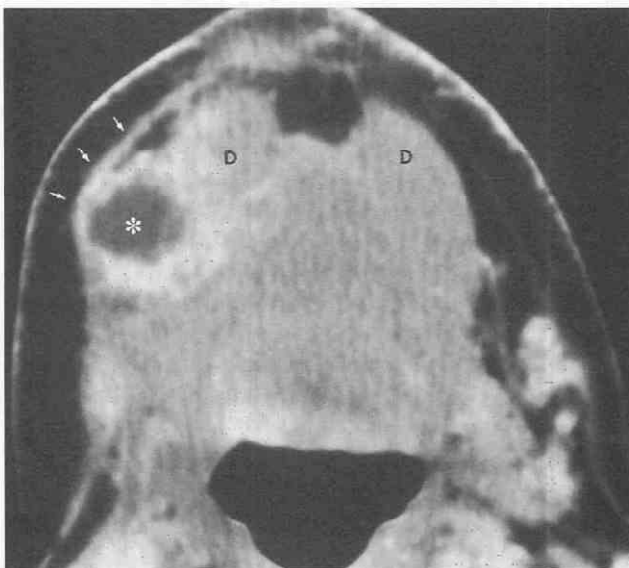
Metastatic lymph node mimicking abscess. Axial contrast-enhanced CT scan demonstrates a low-density right submandibular triangle mass (*asterisk*) surrounded by an irregular rim of contrast enhancement. The overlying platysma muscle is thickened. The patient, who was afebrile, had a history of treatment for squamous cell carcinoma of the right oropharynx 2 years before this examination. Needle aspiration of the mass yielded atypical squamous cells.
